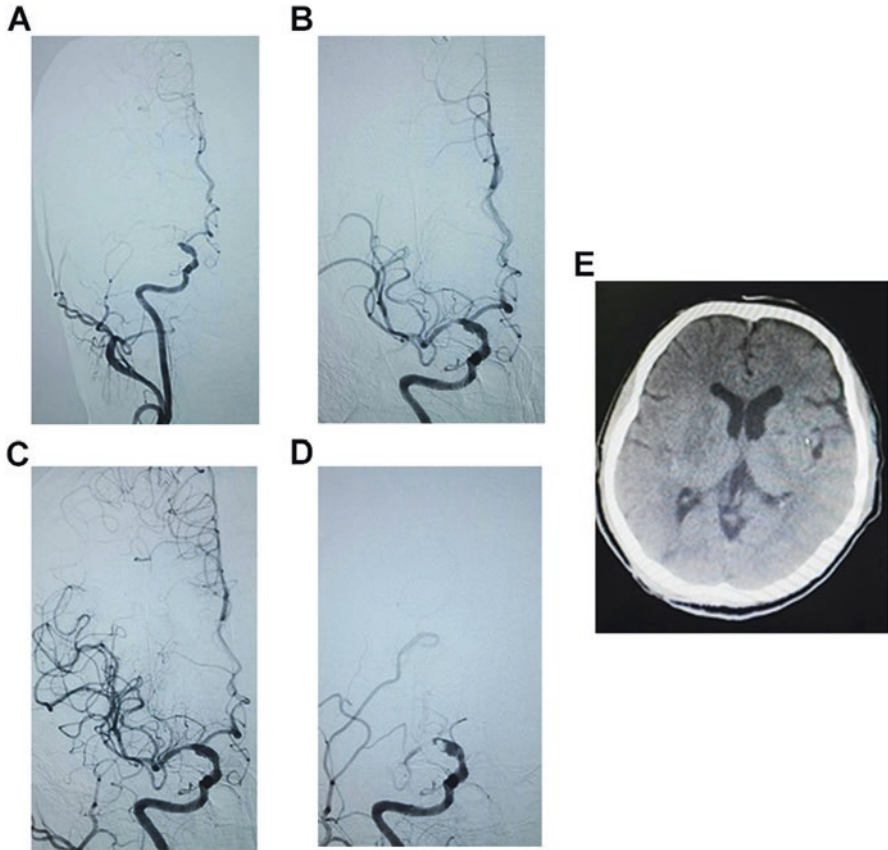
Case II: unsuccessful recanalization leads to small infarction. Male patient, 61-year-old with smoke history, suffered with left limb paralysis and alalia for 5 h. Physical examination indicated dysarthria, left facial paralysis, left arm muscle strength level zero, left leg muscle strength level I, and the National Institutes of Health Stroke Scale (NIHSS) is 15 point. During surgery, the digital subtraction angiography (DSA) indicated the stenosis in the proximal of middle cerebral artery with thrombosis in the far-end of this vessel (a, b). After thrombolectomy and balloon dilatation, DSA showed successful recanalization (c). But 5 min later, the artery occluded again (d). Clearly, this is a patient with middle cerebral artery occlusion for a long time, way beyond the suggested recanalization time window. But, surprisingly, physical examination at 24 h after surgery indicated clear consciousness, mild dysarthria, left arm muscle strength level IV, left leg muscle strength level V, with 3 point on NIHSS. More importantly, the head computed tomography (CT) examination did not show large infarction exist (e)
